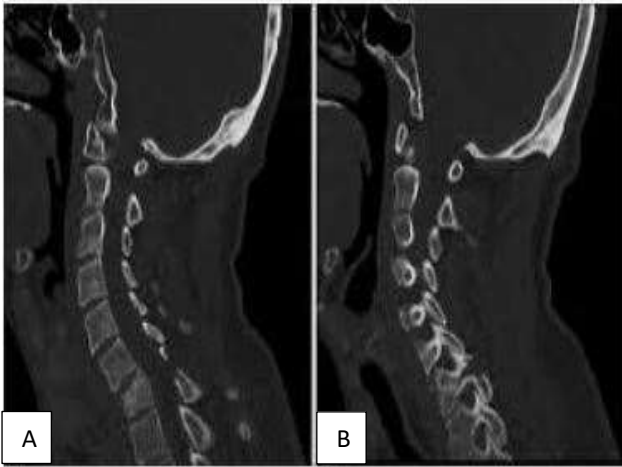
CT cervical spine fracture showed multiple fractured vertebrae. (A) Multiple cervical vertebral fractures, including C5 transverse process, C6 vertebral body, and C6 posterior column, and C7 transverse process comminuted fracture, (B) an MRI scan of a 36-year-old woman's cervical and thoracic spine revealed fracture-dislocation at T6-T7 vertebral stages, with left anterolateral displacement and overriding of the T6 vertebral bodies over the T7 vertebral bodies.
